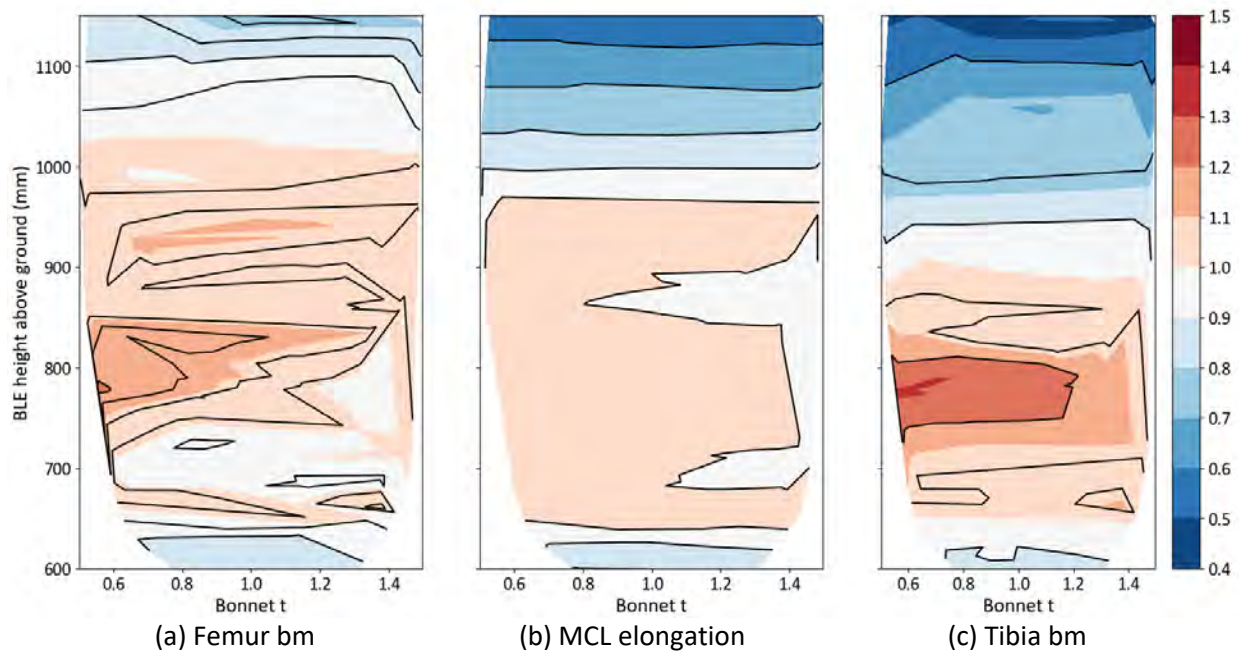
Normalised maximum aPLI injury values at test position Y0 for the SUV by varying the exterior sheet thickness of the bonnet and the shooting height of the impactor (converted to BLE height above ground).
